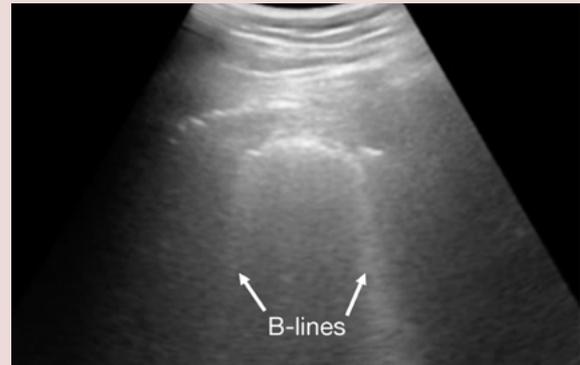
Lung ultrasound changes in mild case of COVID-19: B-lines as sign of the interstitial oedema.
